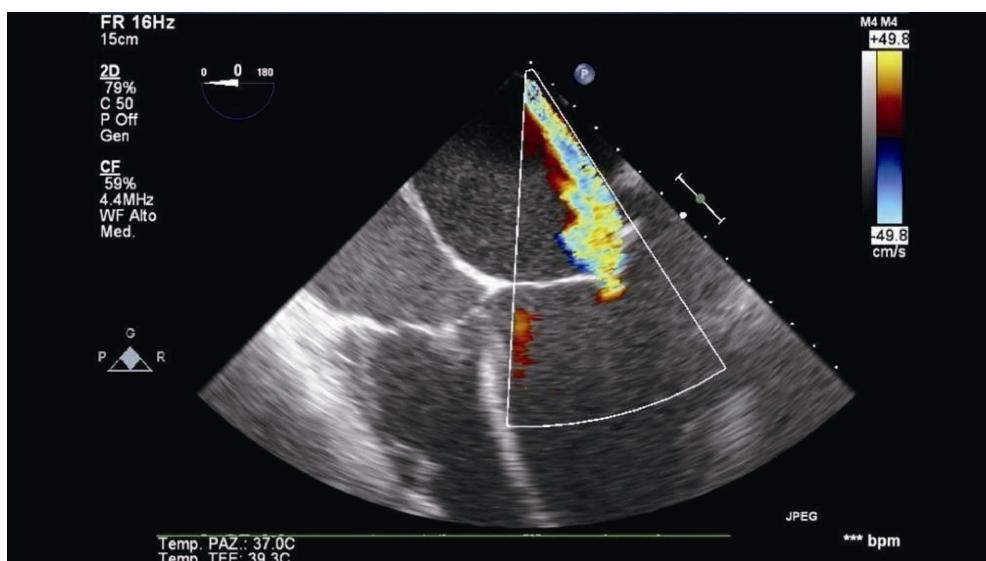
Before MitraClip: TEE showing incomplete systolic leaflet coaptation, leaflet tethering with severe (4+) eccentric MR jet [jet area on mitral leaflet scallops (A2-P2), two jets (P1-A2), (P3-A2)]. MR: Mitral Regurgitation; TEE: transesophageal ecocardiography.
